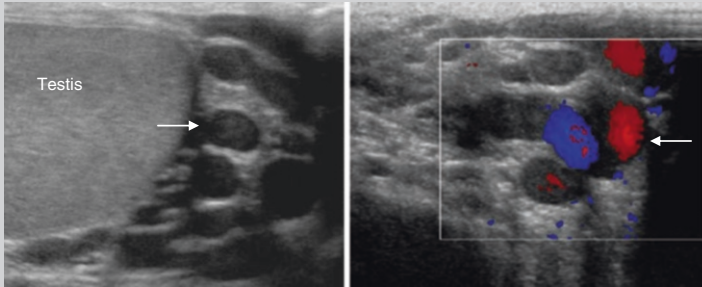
Scrotal ultrasound showing enlarged veins with hypervascular flow on colour Doppler in the left scrotum consistent with varicocele (*arrows*)
